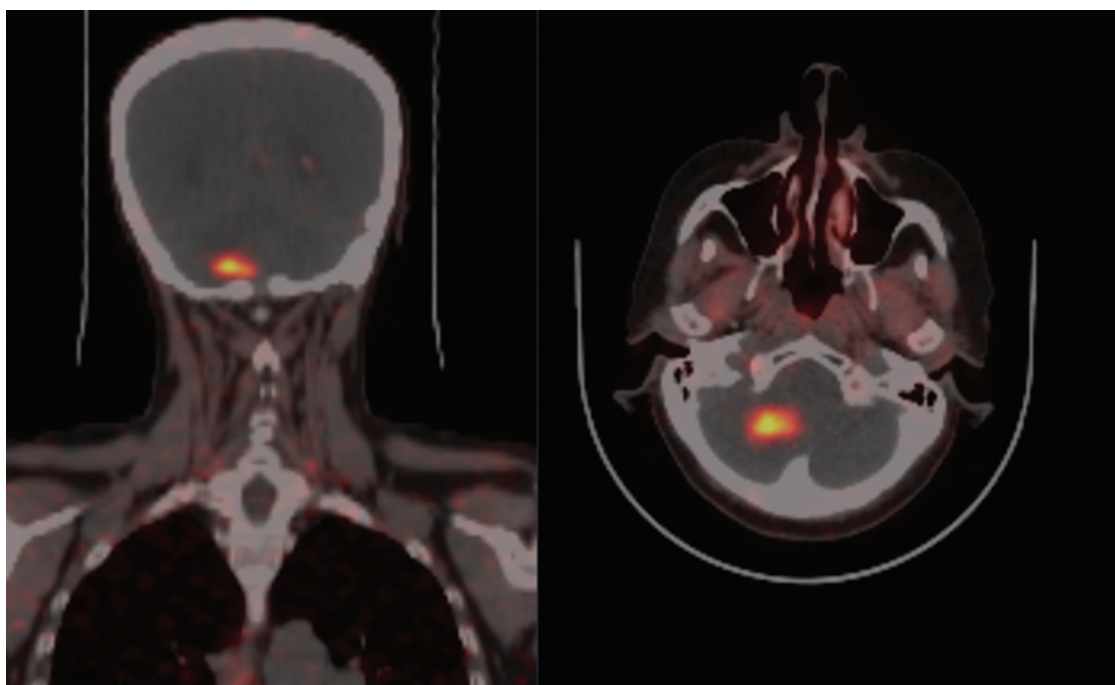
A right cerebellar hypermetabolic mass measuring 19 × 21 mm on PET/CT.
